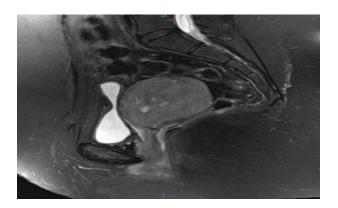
MRI in T2 phase. Sagittal plane image of tumor that depends of the vagina in its upper part of 69×66 mm.
